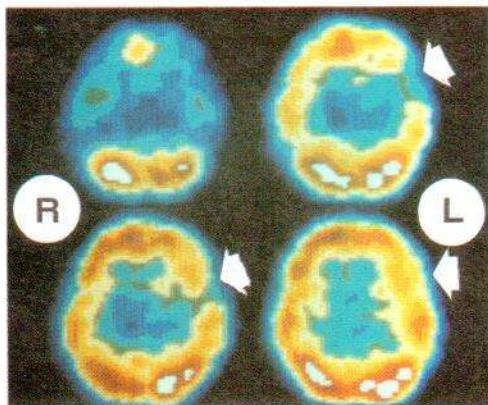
Four-year-old girl with focal epilepsy and left temporal EEG focus. Inter-ictal SPECT showed hypoperfusion in corresponding area of left temporal lobe.
